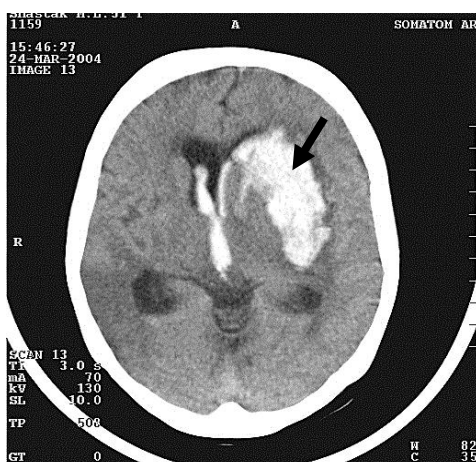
The x-ray computer tomogram of a brain. A hemorrhage in left hemisphere and ventricles of a brain, forming hyperdensity zones (arrow)
